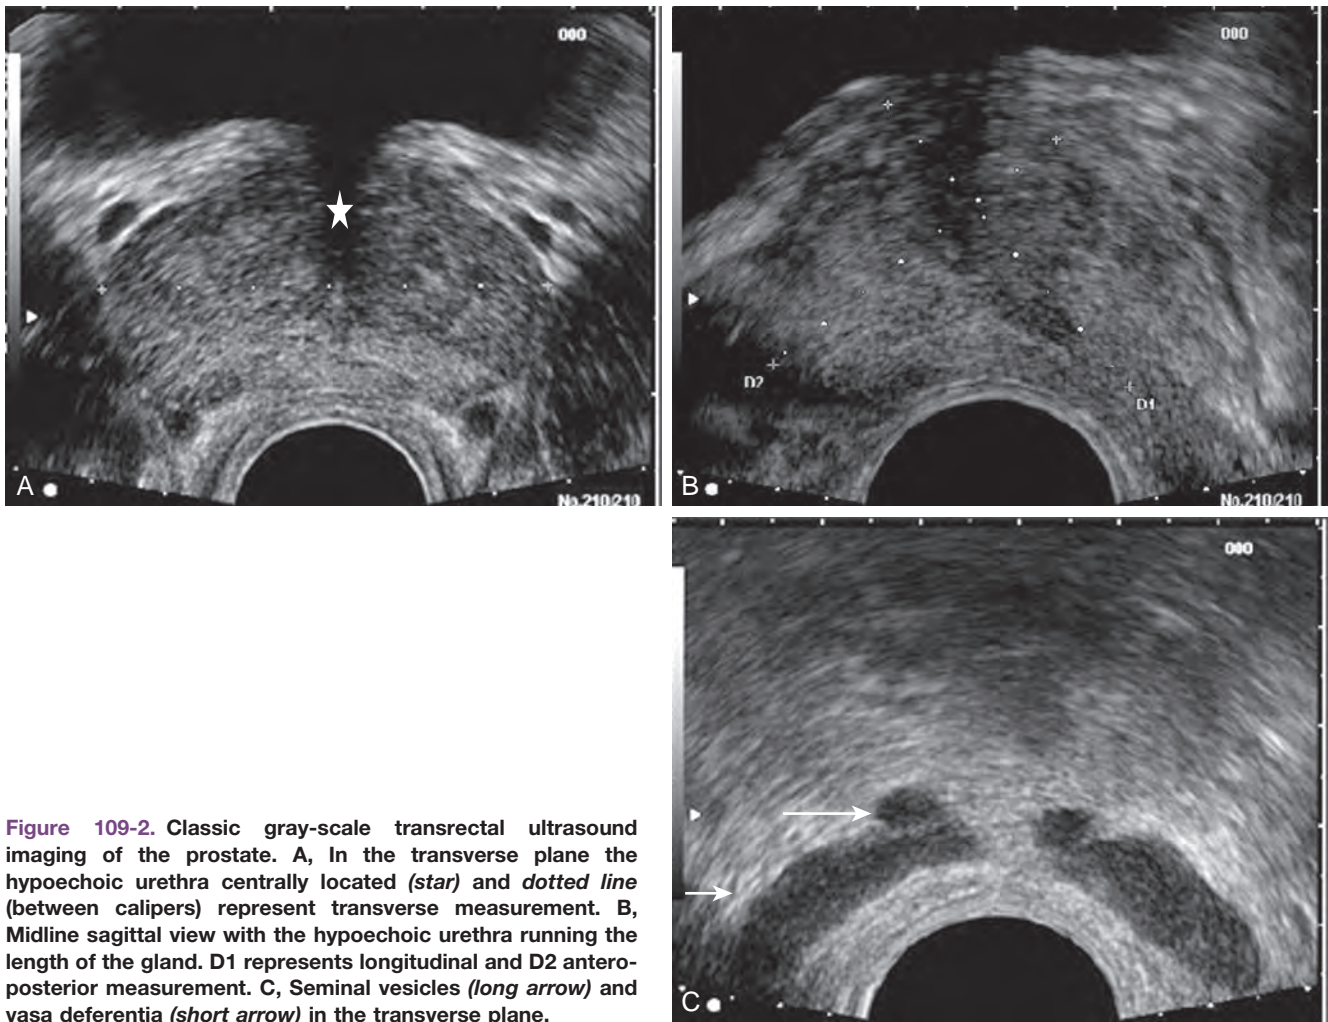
Classic gray-scale transrectal ultrasound imaging of the prostate. A, In the transverse plane the hypoechoic urethra centrally located (*star*) and dotted line (between calipers) represent transverse measurement. B, Midline sagittal view with the hypoechoic urethra running the length of the gland. D1 represents longitudinal and D2 anteroposterior measurement. C, Seminal vesicles (*long arrow*) and vasa deferentia (*short arrow*) in the transverse plane.
